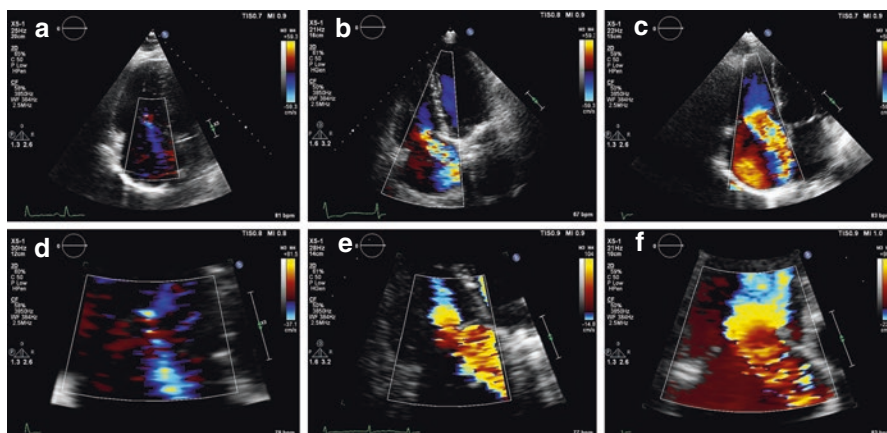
Optimal visualization and measurement of TR jet vena contracta on colour Doppler in a patient with mild (a, d), moderate (b, e) and severe (c, f) TR
